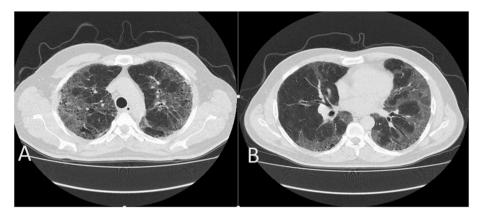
Interstitial lung disease findings (mosaic pattern, ground glass opacity, honey comb pattern) in HRCT at the initial admittance.
